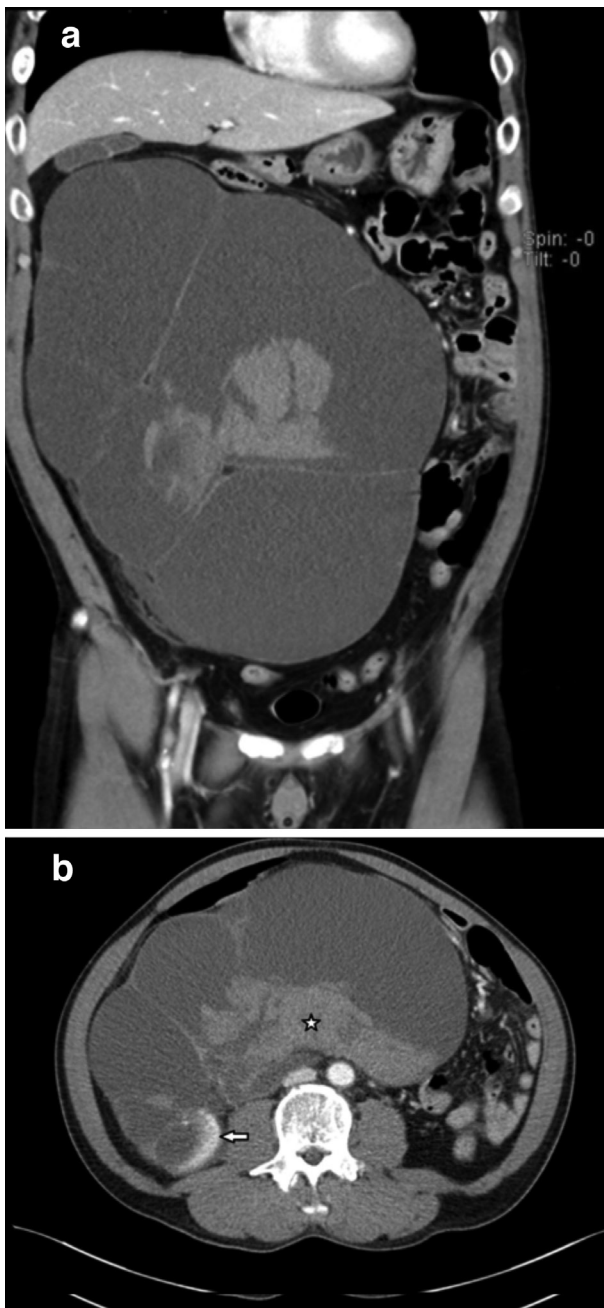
Computed tomography images in coronal (a) and axial (b) sections showing; a) The huge renal mass is seen here displacing the abdominal organs, b) Note an area of avid enhancement posteriorly (arrow), and minimal enhancement of the renal parenchyma with a central solid heterogenous focus (star); which was initially thought to represent a tumor/hematoma
